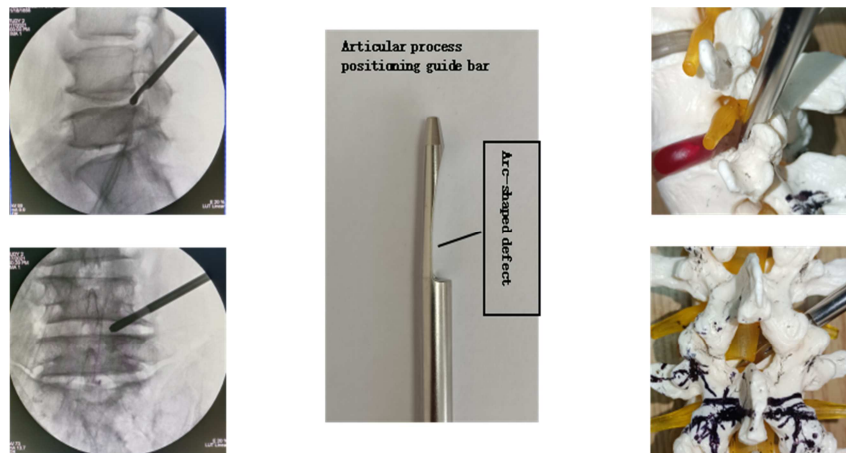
X-ray fluoroscopy confirming that the tip of the facet guide rod passed through the foramina and reached the lateral recess.
